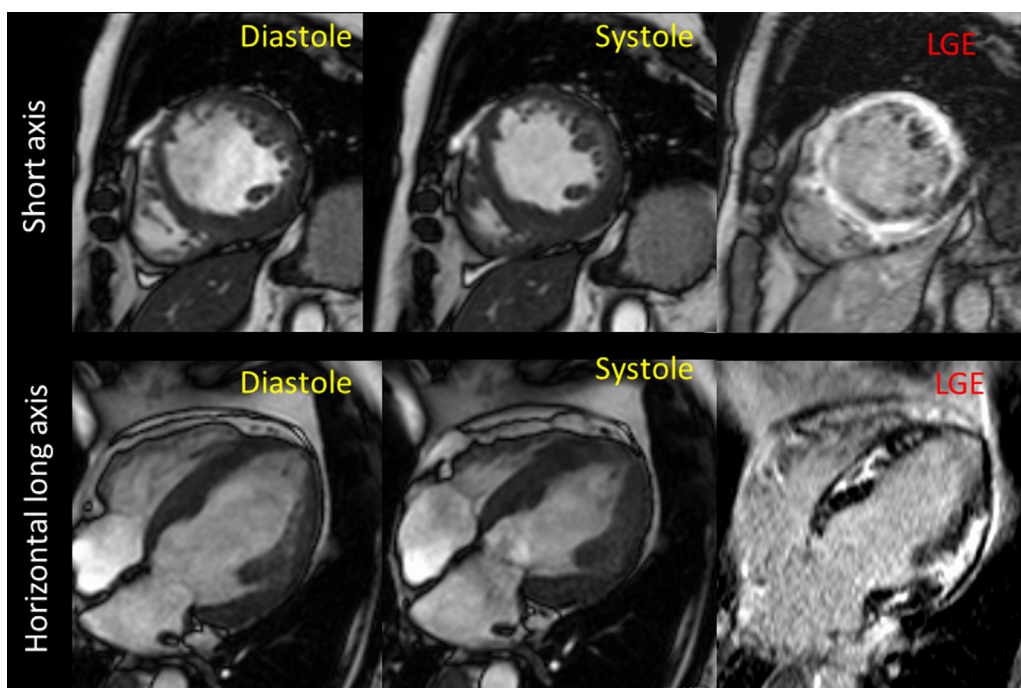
Cardiac magnetic resonance imaging (CMR). CMR showed the thinning of the basal septum. Late gadolinium enhancement (LGE) showed a significantly increased signal intensity in anteroseptal area, and entire circumference of the area of basal and lateral wall.
